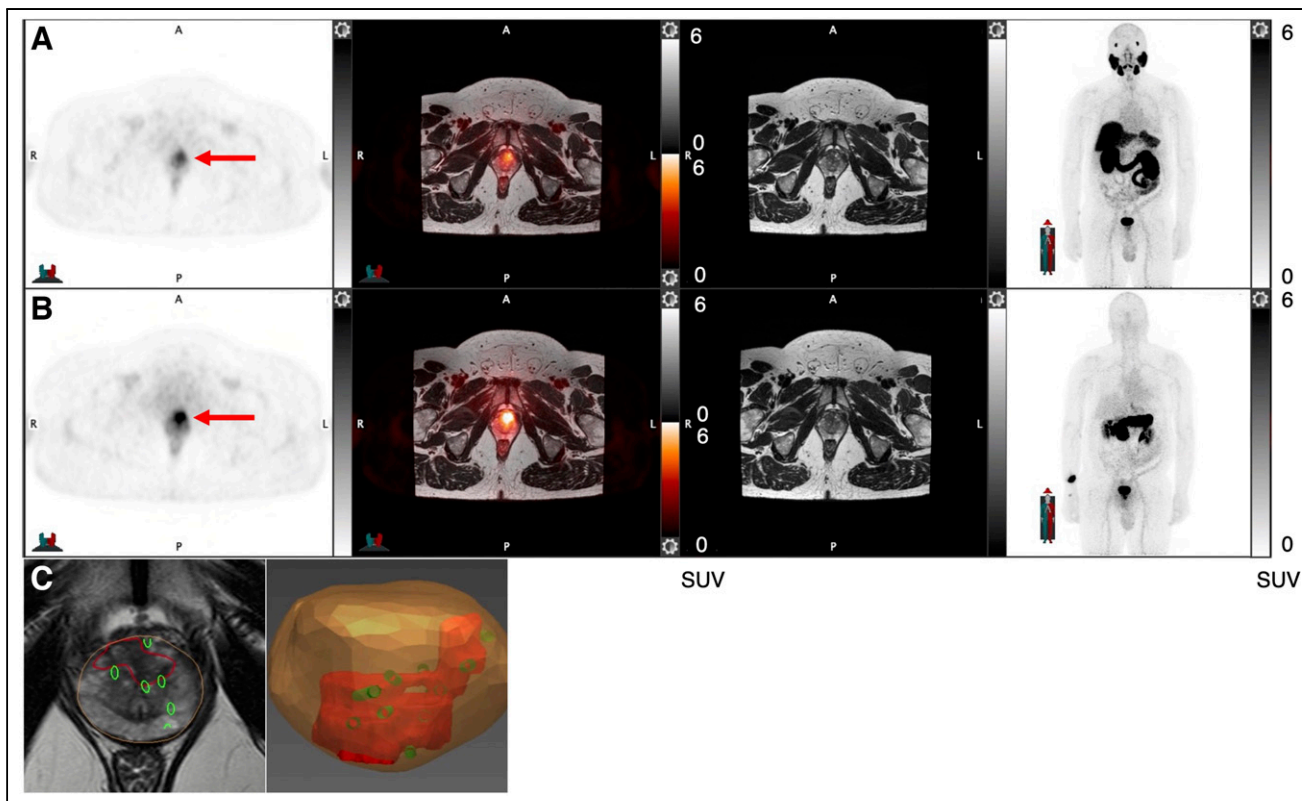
A 58-y-old man presenting with PSA of 12.8 ng/mL and PSA density of 0.41 ng/mL². (A and B) ⁶⁸Ga-RM2 (B, axial PET [left-most image], fused PET/MRI [second image], MRI [third image], and maximum-intensity-projection images [right-most image]) shows intense uptake in anterior prostate (red arrows), which is less pronounced on ⁶⁸Ga-PSMA11 PET/MRI (A). PET-guided biopsy demonstrated Gleason 3 + 4 prostate cancer. (C) Coregistration of biopsy needle tracks are shown in green; index tumor is outlined in red on mpMRI as well as on 3-dimensional-rendered image. A = anterior; P = posterior.
